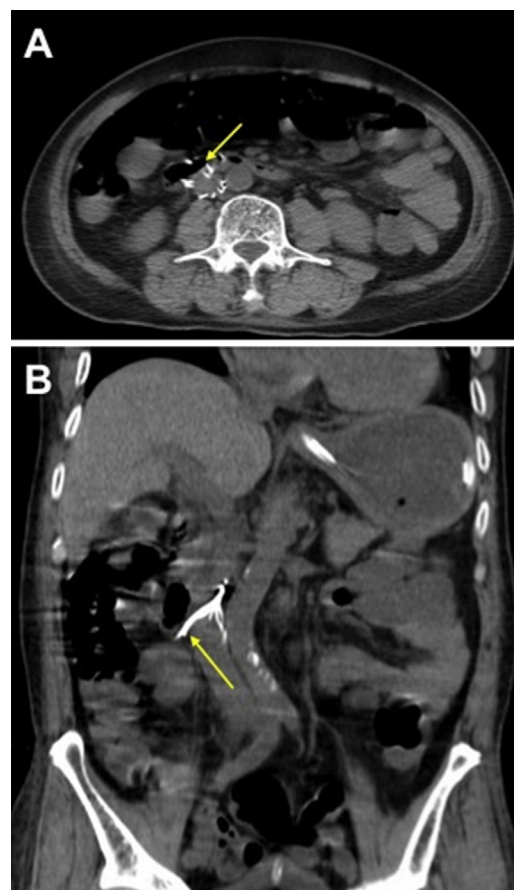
(A and B) Axial and coronal CT views of abdomen and pelvis demonstrating the perforation of retrievable IVC filter tines through IVC into duodenum (yellow arrows). (For interpretation of the references to colour in this figure legend, the reader is referred to the web version of this article.)
